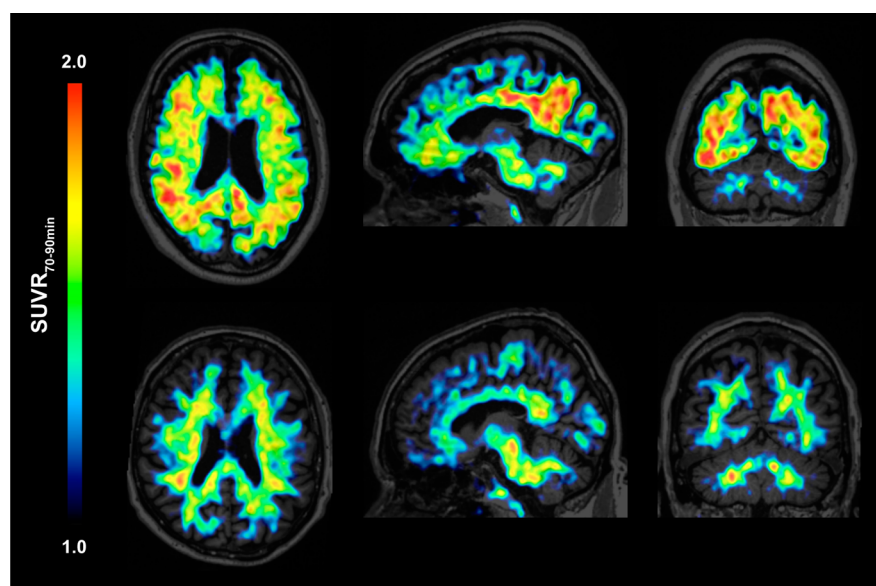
First human brain PET/MR images with [^{18}F]FIBT. PET images of a patient with moderate Alzheimer's disease (top) and a subject defined as control (psychometric testing within normal limits, normal FDG PET, and normal CSF τ , τ^* , and $A\beta_{1-42}$ levels) (bottom) coregistered to their corresponding T1-weighted MPRAGE MR images as taken with the Siemens Biograph in a fully dynamic 90 min PET/MR study. 70–90 min postinjection frames are shown as axial (left), sagittal (middle), and coronal (right) views. PET data was transformed to standardized uptake value ratios (SUVRs) using the cerebellum as reference region (scale on left side). Images from the patient with tracer distribution typical for AD (top) show strong contrast to images from the subject (bottom) who was cleared of any signs of neurodegeneration with a tracer distribution typical for healthy controls. Vertical color bar indicates look-up-table “Cold” (taken from Pmod) between ratio values of 1.0 (i.e., equality) and 2.0.
